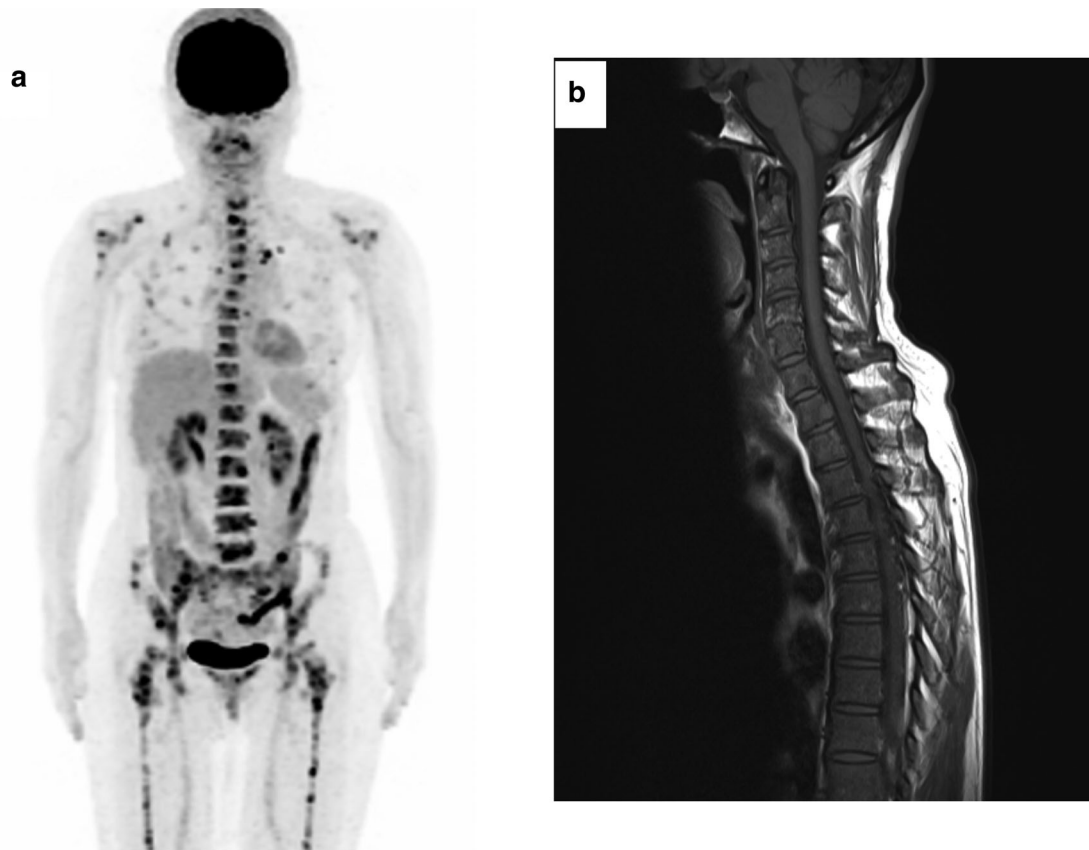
(a) Positron emission tomography with ^{18}F -fluorodeoxyglucose-positron emission tomography/computed tomography (18-FDG-PET/CT) showed diffuse and multiple FDG uptake in the thoracolumbar spine and iliac-sacrum, femur, and rib areas. (b) Magnetic resonance imaging on fat-suppressed contrast-enhanced T1-weighted images showed heterogeneous infiltration of the vertebra, suggesting multiple bone metastases
